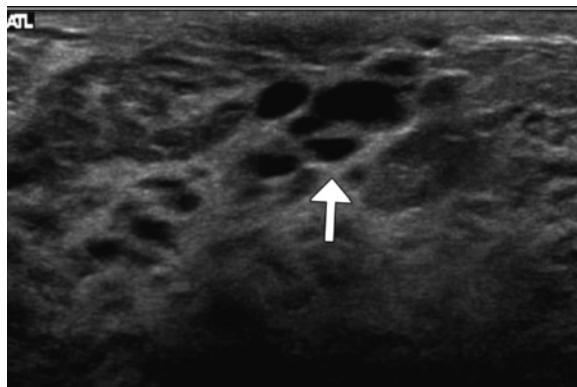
Retroareolar duct ectasia in a young pregnant woman. Sonogram demonstrates dilated anechoic ducts (arrow) seen in cross section deep to the areola.
